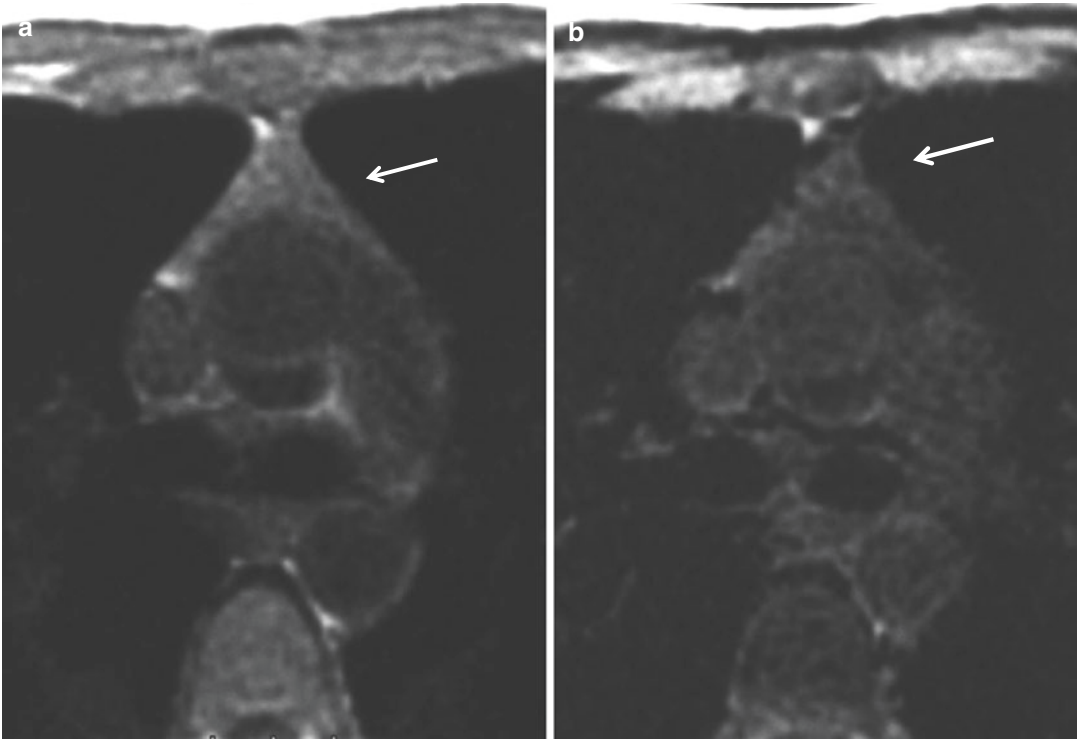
Normal thymus in an 18-year-old girl. Chemical shift T1-weighted MR images. The thymus shows a homogeneous decrease in signal intensity at opposed-phase image (b) contrast to in-phase image (a) (arrows)
